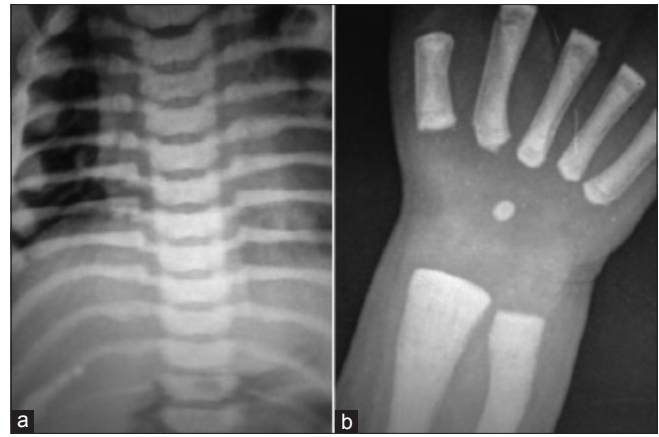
(a) X-ray chest showing spatula shaped ribs with thickening of ends; (b) Erlenmeyer flask deformity of distal ends of Radius and Ulna
